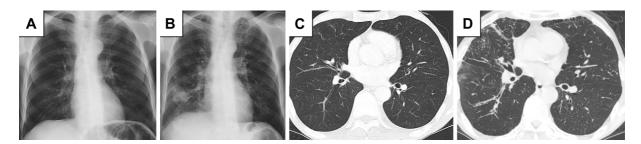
Imaging findings three years before ABPA development and after two years of anti-TNF- α antibody therapy. Imaging findings three years before ABPA development show no abnormalities (A, C) but support a diagnosis of ABPA two years later (B, D). Chest radiograph (B) shows consolidation in the middle and lower areas of the right lung. Chest computed tomography (D) shows airspace consolidation, ground glass opacity, and central bronchiectasis in the lower lobe of the right lung. ABPA: allergic bronchopulmonary aspergillosis
